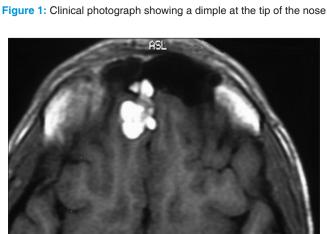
Axial T1 MRI image showing a hyperintense lesion
